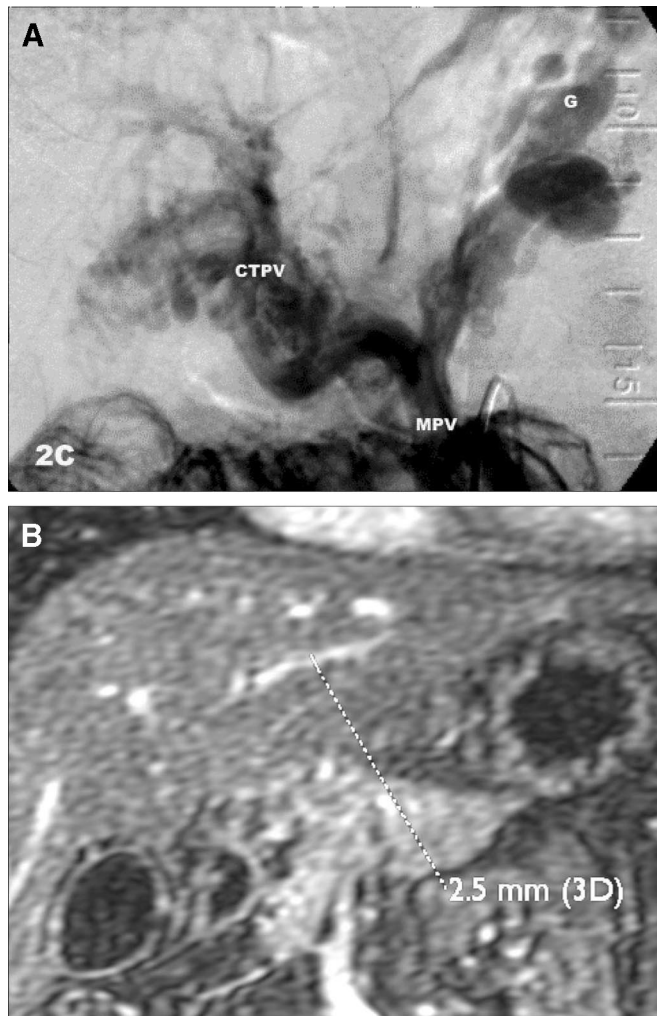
A, Conventional angiography usually failed to demonstrate the size or presence of an intact intrahepatic portal vein because the contrast filled the cavernous transformation (CVTP) in the hilum of the liver or flowed into the coronary vein (G). B, Magnetic resonance (MR) or computed tomography (CT) angiography usually demonstrated and allowed precise measurement (2.5 mm) of the portal vein diameter in the left lobe of the liver as indicated here by the dotted line.
